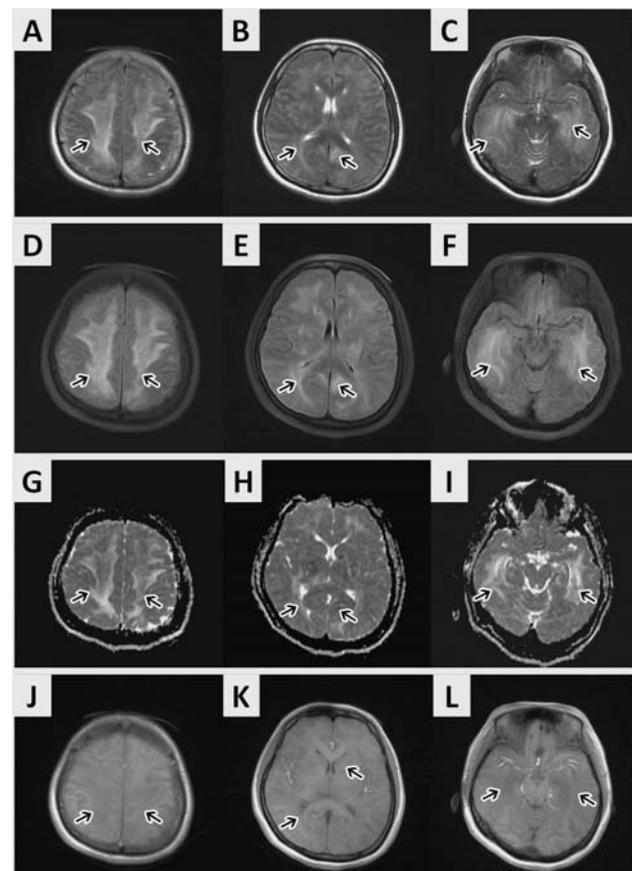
Brain MRI revealed severe brain edema and extensive symmetric white matter lesions, without enhancement. A-C) T2 weighed images; D-F) Fluid-attenuated inversion recovery (FLAIR); G-I) Apparent diffusion coefficient maps; J-L) Enhanced MRI-T1 weighed images.
